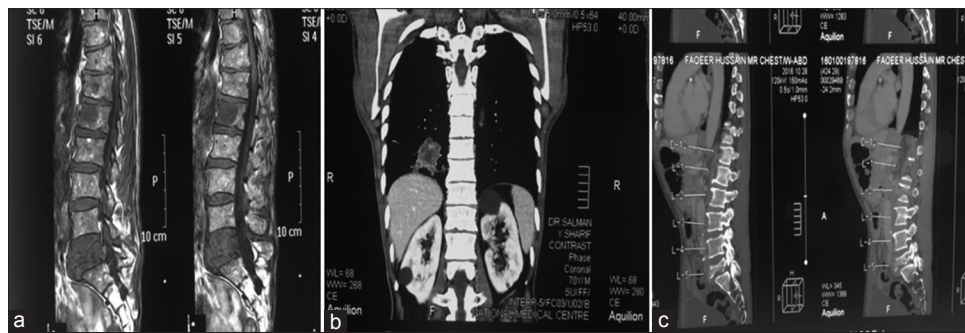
Case 2: A 60-year-old male with back pain and sciatica for 1 month. He had diffuse metastatic disease with Lung lesion and bone metastases. He had a stable posterior column and L5 compression. This patient was managed conservatively. His Modified Tokouhashi score- 4, Tomita-10, Modified Bauer-I and SINS score 14. The prognostic scores estimated his survival to be less than 6 months; hence this patient was managed conservatively. (a) MRI dorsolumbar spine (sagittal view) showing spinal metastases at L5 and L1. (b) Coronal CT chest showing the primary lesion involving lower zone of right lung. (c) Sagittally reconstructed CT of lumbosacral spine showing compression of L5 vertebra
